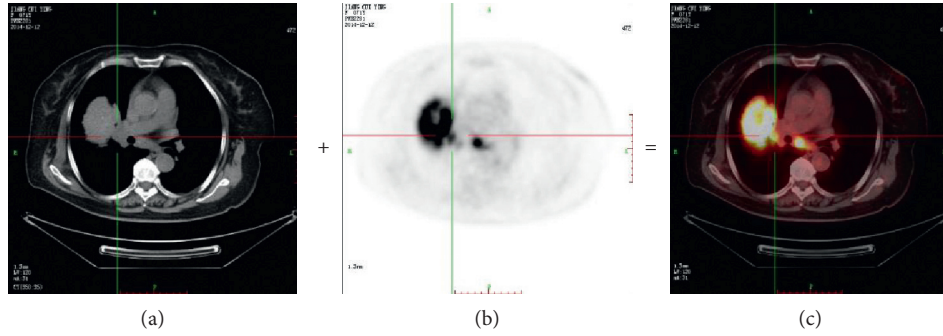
The source image of CT, PET, PET/CT.
